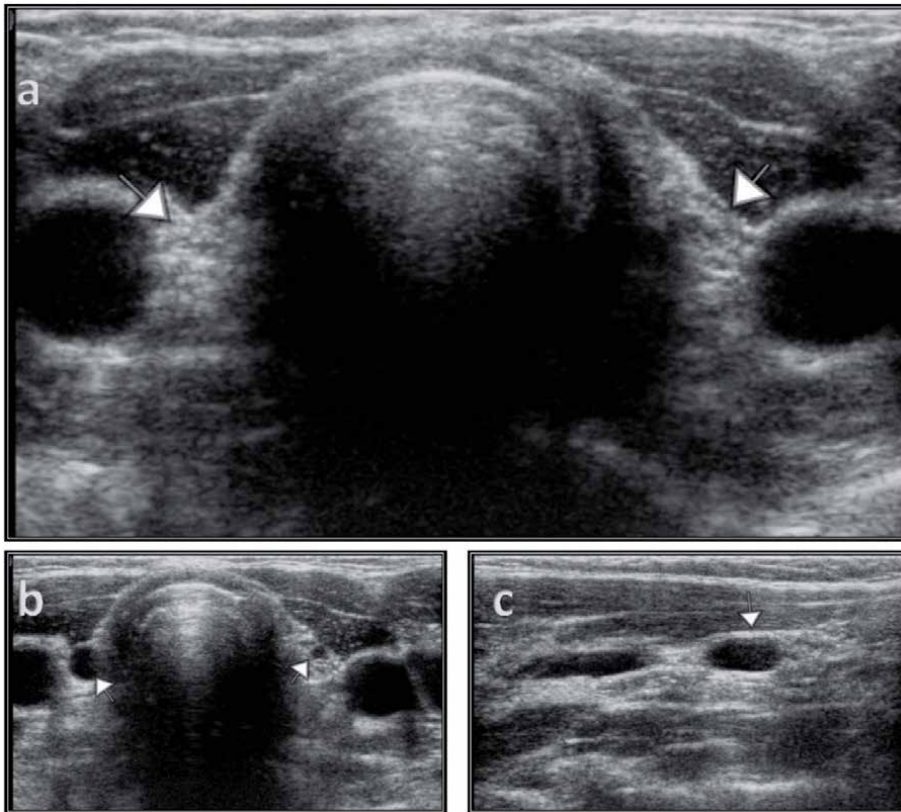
(a) Athyreosis, empty thyroid lodge caused by agenesis. The arrows indicate echogenic triangles, representing ultimobranchial and connective tissue residue. (b) In the transverse and (c) sagittal planes, as in this case, there are bilateral cysts (arrows), also called ultimobranchial cysts, in the empty thyroid lodge. There is no flow on Color Doppler Imaging (not shown). (Courtesy of Prof Dr. Suat Fitoz from his archive. Department of Pediatric Radiology, Ankara University School of Medicine, Ankara/Turkey).
